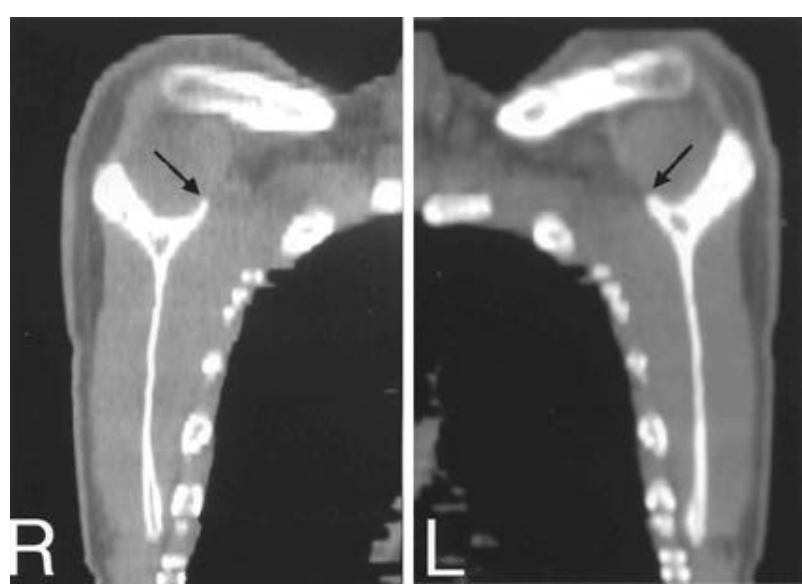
Postoperative sagittal CT image of both scapula. The black arrows show the edge of removed superior angle of both scapula.
